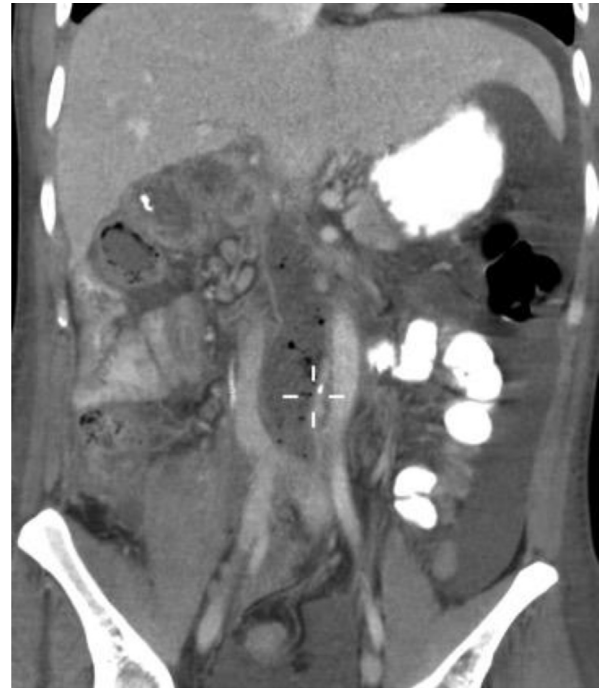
A coronal computed tomography scan of the reconstruction 30 days after the operation. As demonstrated here, the inferior vena cava (IVC) is patent, and the patient is doing well.
